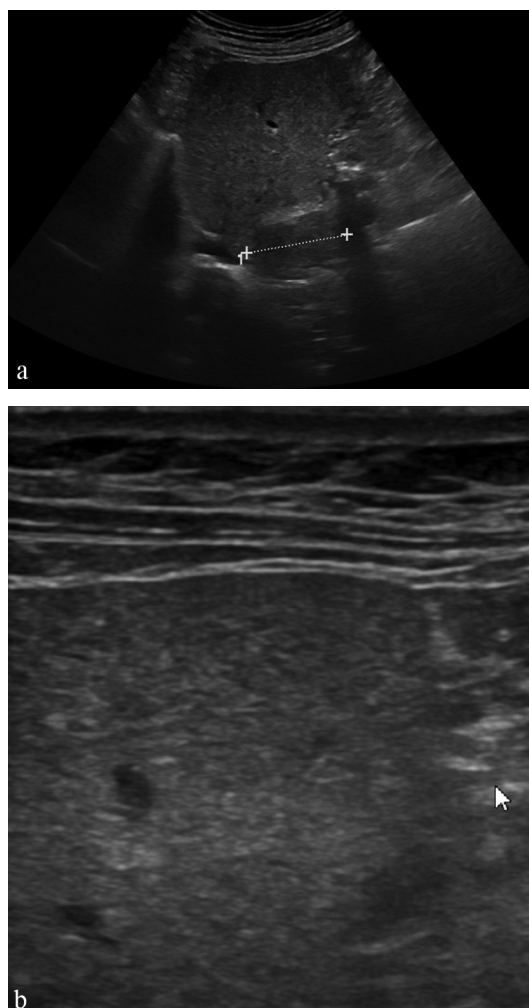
Ultrasound findings suggestive of advanced liver fibrosis in the patient showed a) changes in volume distribution including an enlarged caudate lobe and b) nodular liver contour with inhomogeneous liver parenchyma with the linear probe.
